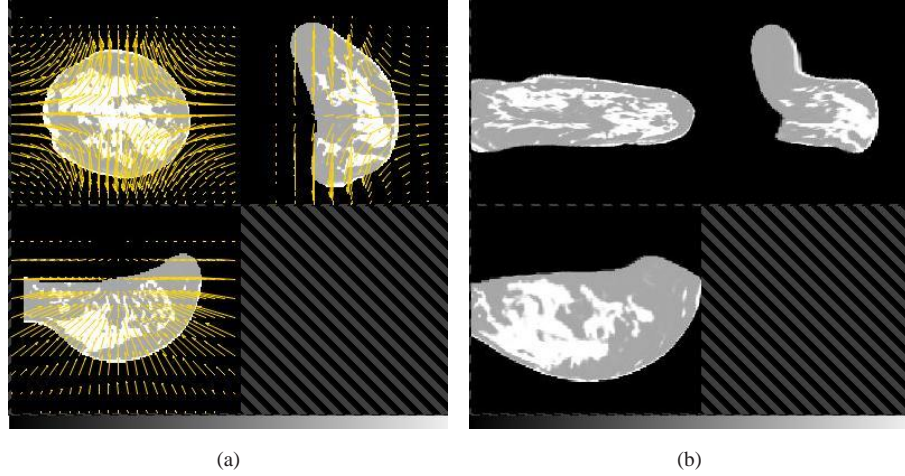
(a) An example of an X-ray attenuation volume superimposed with the displacement field of the mean PCA component and (b) the same volume after the mean deformation.
